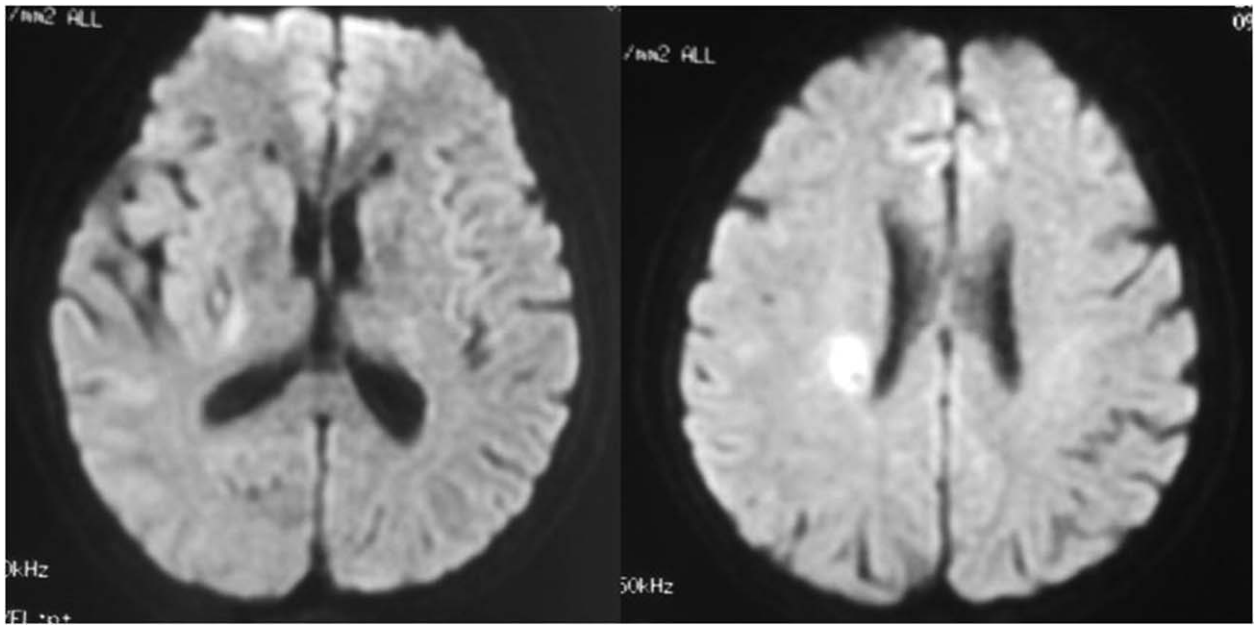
MRI shows acute cerebral infarction in right side of basal ganglia and lateral ventricle. MRI=magnetic resonance imaging.
